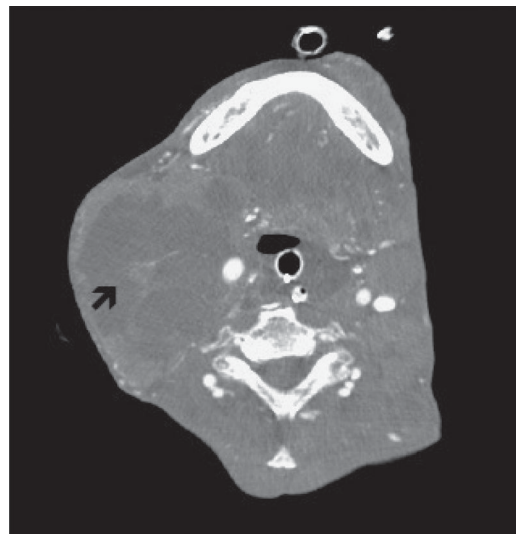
Computed tomography neck. Black arrow denoting large cervical lymphadenopathy.
